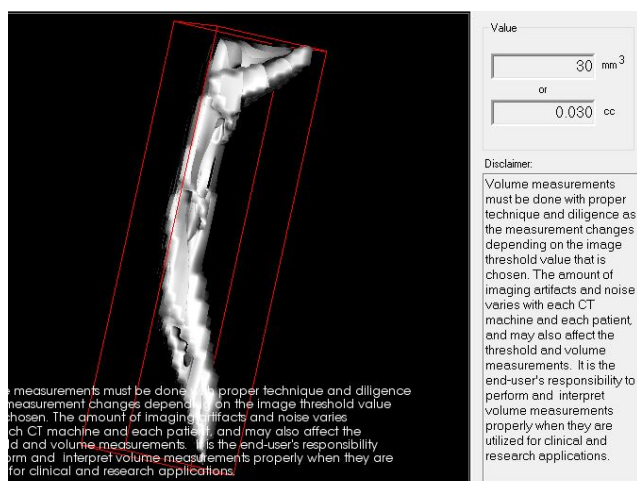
Pre-operative scan calculating volume of the canal using CBCT
